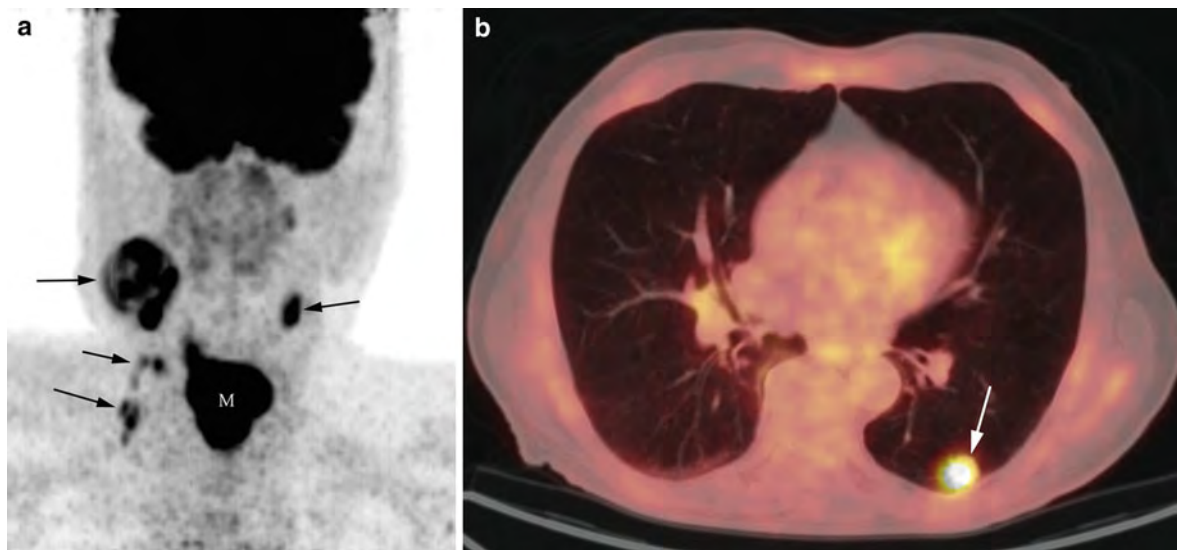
Coronal PET image (a) of the neck demonstrates a large hypopharyngeal mass (*M* in a) with bilateral metastatic lymph nodes (*arrows* in a). The axial fused PET–CT image
